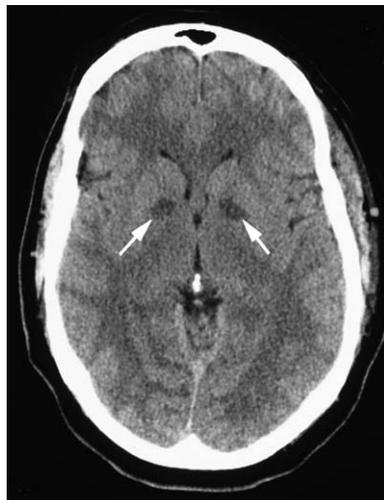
Bilateral globus pallidus lesions seen on CT of the brain after CO poisoning.
